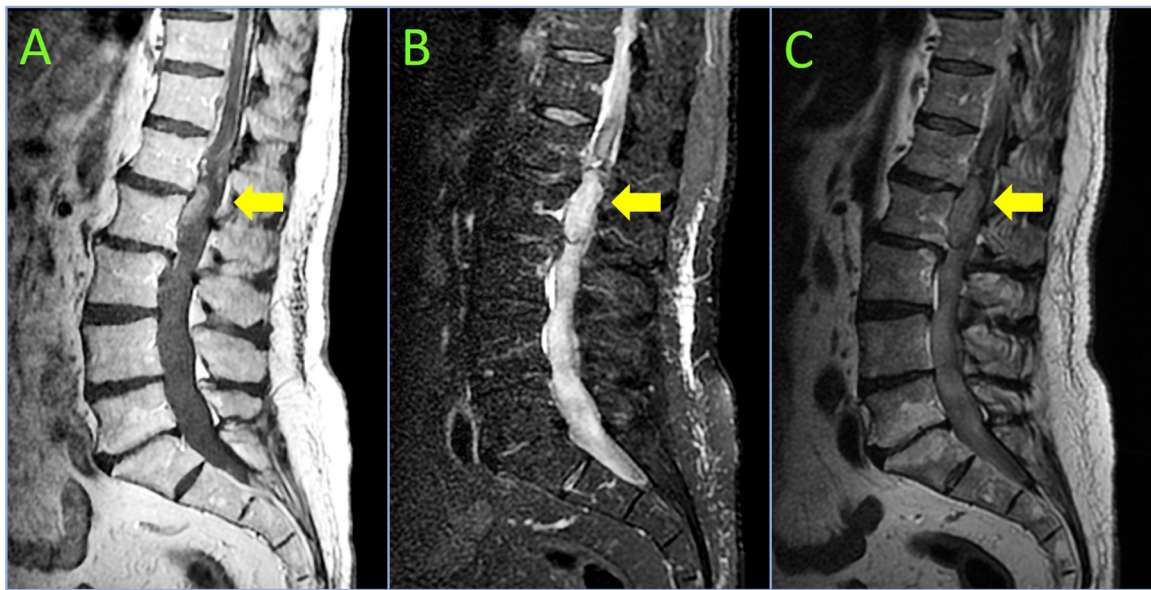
Sagittal (B) T1-weighted (A), T2-weighted FrFSE (B) and T2-weighted FrFSE fat sat (C) magnetic resonance images revealing a large omogeneously hyperintense intradural lesion (yellow arrow) extending from L1 to L2, with enhancement after gadolinium and flow voids cranial to the mass indicative of venous congestion or high vascularity of the tumor.
